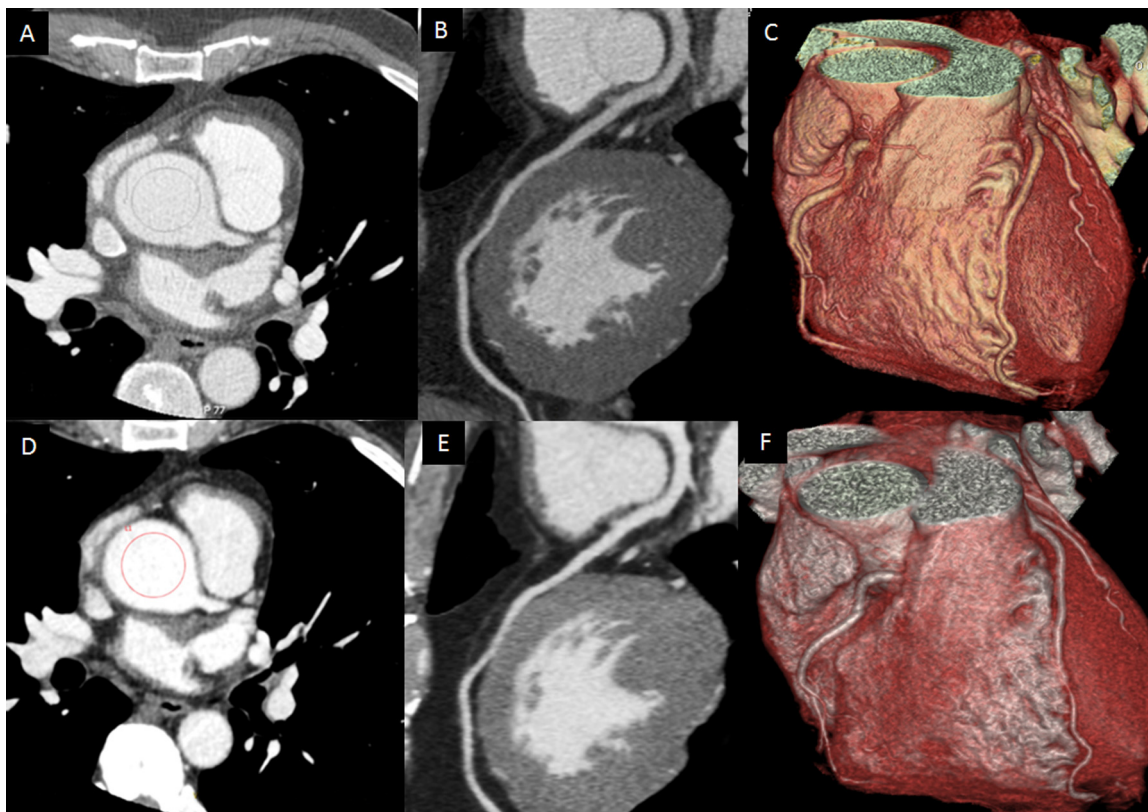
Fifty-three year old male with normal coronary arteries. Single energy CT coronary angiography (above, panels A–C) performed with 70 ml of iodinated contrast and dual energy CT coronary angiography performed with 35 ml of contrast and reconstructed at 60 keV with 40% ASIR. In panels A and D, the region of interest shows a mean signal density of 328HU and 304HU, and a mean noise of 34 HU and 19 HU for SE-CTCA and DE-CTCA, respectively.
